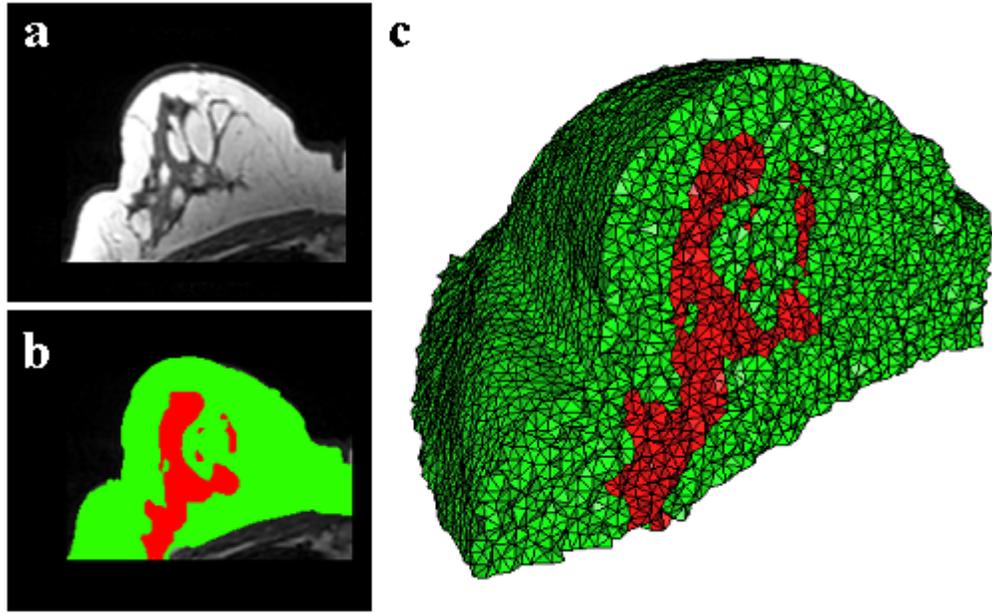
(a) Original MRI slice of the breast, (b) segmentation of different tissue types, and (c) the 3D tetrahedral mesh for the breast, showing the regions as different colors: red is the glandular tissue, and green is other breast tissue.
